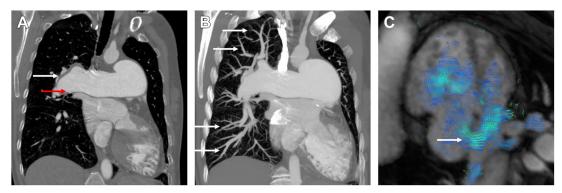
A 43 year old man with in situ thrombus in the setting of unrepaired secundum atrial septal defect. (*A*) Coronal oblique image demonstrates massively dilated central pulmonary arteries. Lining thrombus is seen in the interlobar artery and proximal right upper lobe basal trunk (*white arrow*). Mural atherosclerotic calcification is present (*red arrow*), which is atypical of CTEPH. (*B*) Maximum intensity projection image from the same patient demonstrates patency of the distal segmental/subsegmental arteries, further confirming a non-CTEPH diagnosis. (*C*) A 4 chamber 4D flow MR image demonstrating marked enlarged of the right heart in keeping with pulmonary hypertension with right to left flow through the ASD in this still frame. Due to bidirectional flow, the pulmonary-to-systemic blood flow ratio (Qp/Qs) was 1.1.
